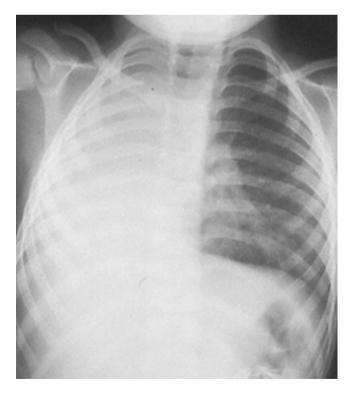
Chest X-ray showing right lung agenesis
